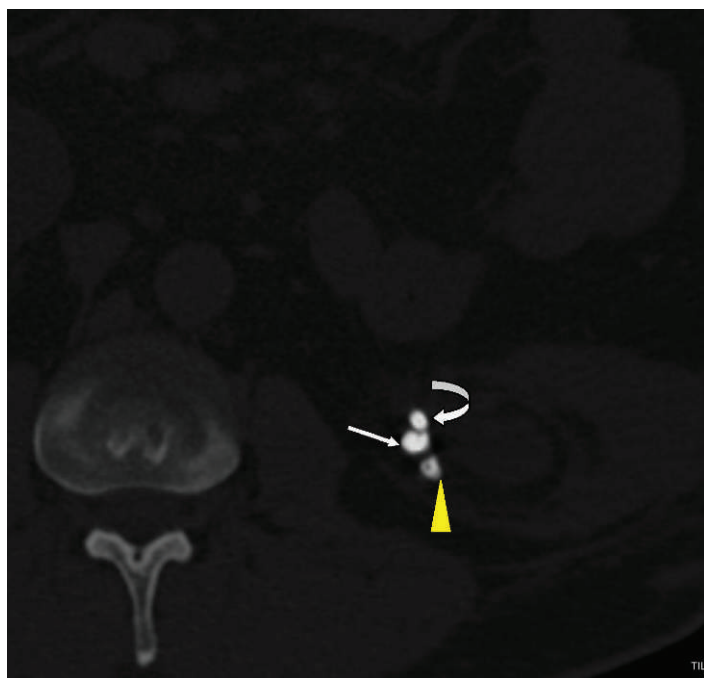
Axial computed tomography (CT) in bone window: importance of appropriate window levels and window widths on CT. Bone windows clearly differentiate the ureteral stent (curved arrow) from the embolization coil (white arrow) and stone forming due to coil acting as nidus (yellow arrowhead).
